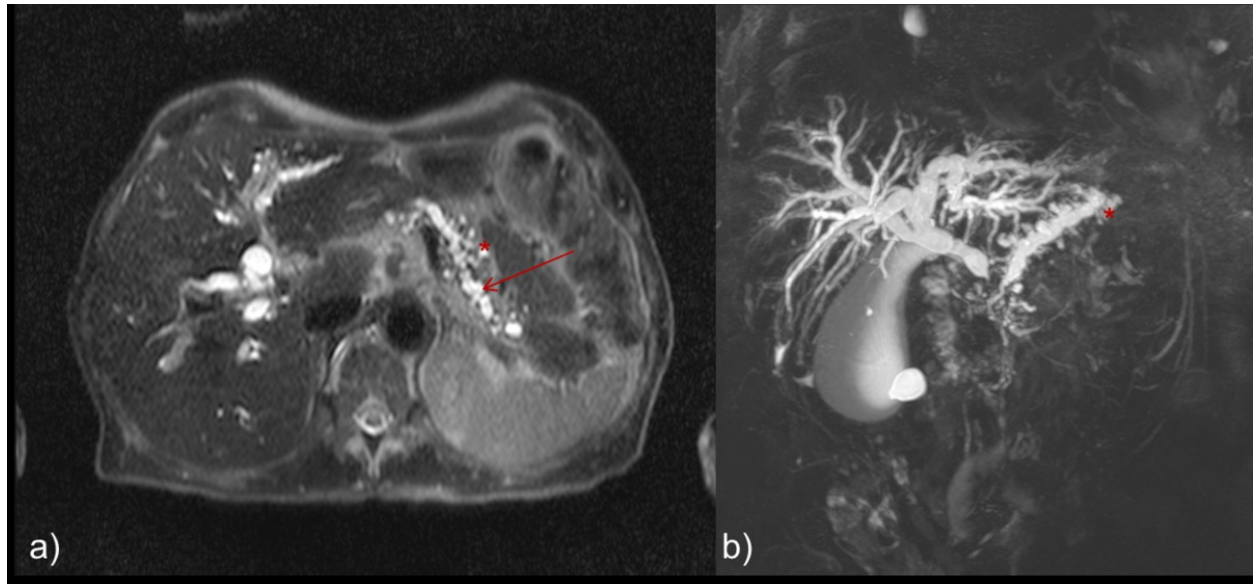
Axial T2-weighted image FSE with fat saturation a) and coronal thick-slab MRCP image b), in a patient with severe chronic pancreatitis demonstrating irregular main pancreatic dilatation and dilatation of several side branch ducts (*), with parenchymal atrophy . Bile duct dilatation is also seen. This patient also had computed tomography examinations, whose findings were suggestive of chronic pancreatitis.
